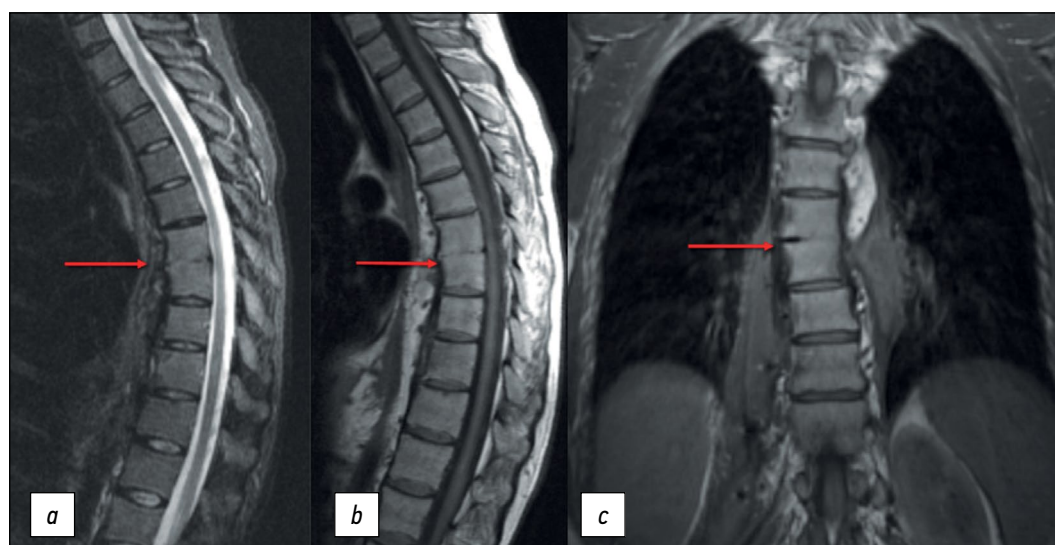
Thoracic spine MRI: (a) STIR mode, sagittal plane; (b) T1WI mode, sagittal plane; and (c) T1WI mode, coronal plane. The arrows indicate bony and fibrous ankylosis ThVII–ThVIII.
